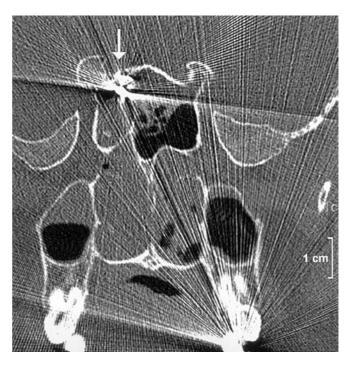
Coronal computed tomography of the head, showing the pellet (*arrow*) in the anterior cranial fossa
